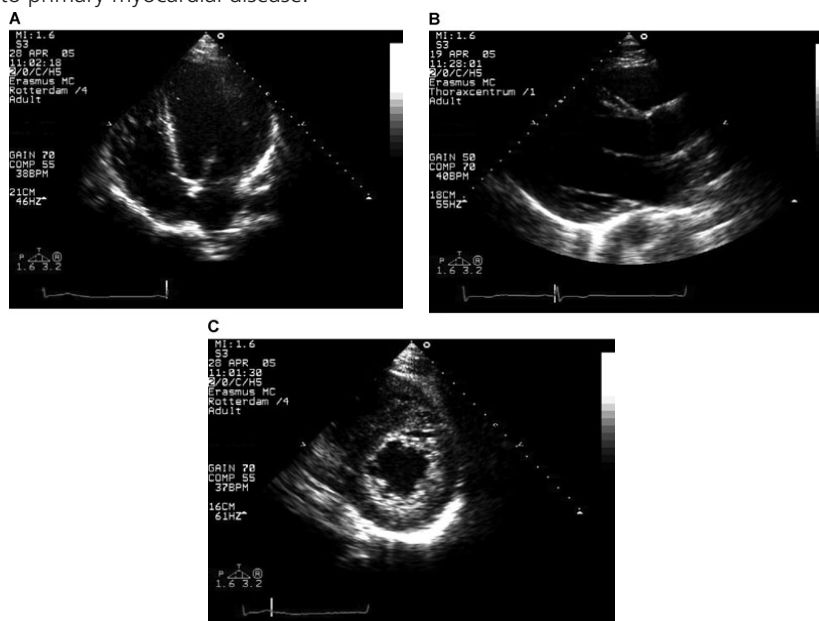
A, B, and C. Echocardiographical left ventricular apical 4-chamber and parasternal long axis views in the end-diastole (A, B) showing severely dilated left ventricular (LV). The parasternal short axis view in end-systole shows excessive trabeculations (C) with 2-layered aspect: a thick noncompacted endomyocardial side and compacted epicardial side of the left ventricular myocardium (noncompacted/compacted ratio > 2).
